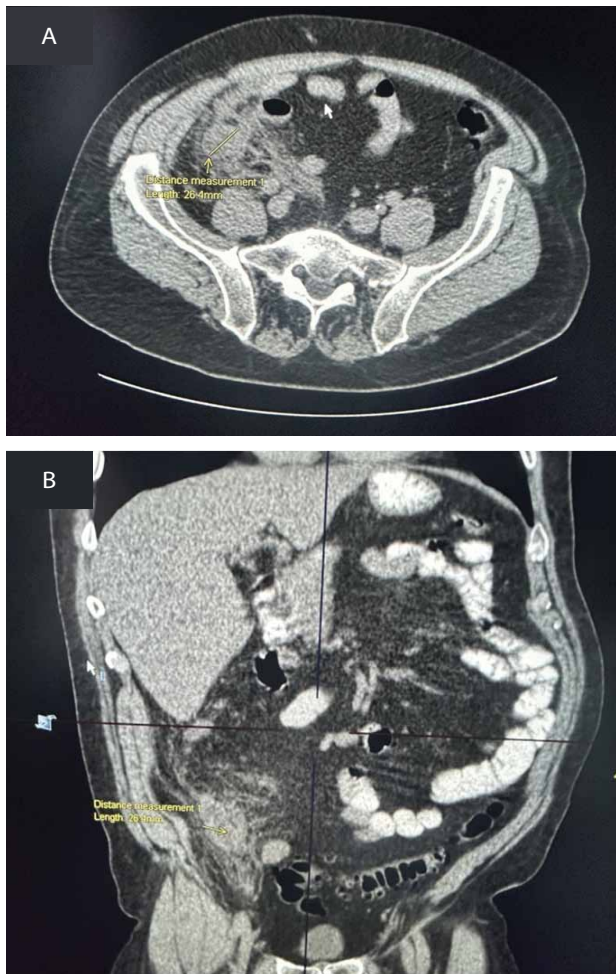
CT showing enlarged appendix and pericolic fat thickening.
